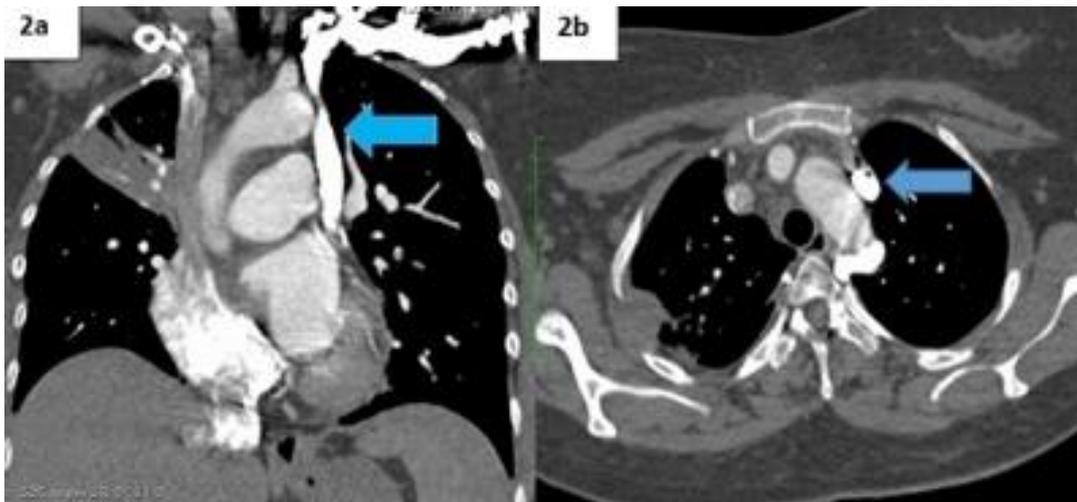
CT thorax shown the presence of persistent left superior vena cava (grey arrow)
